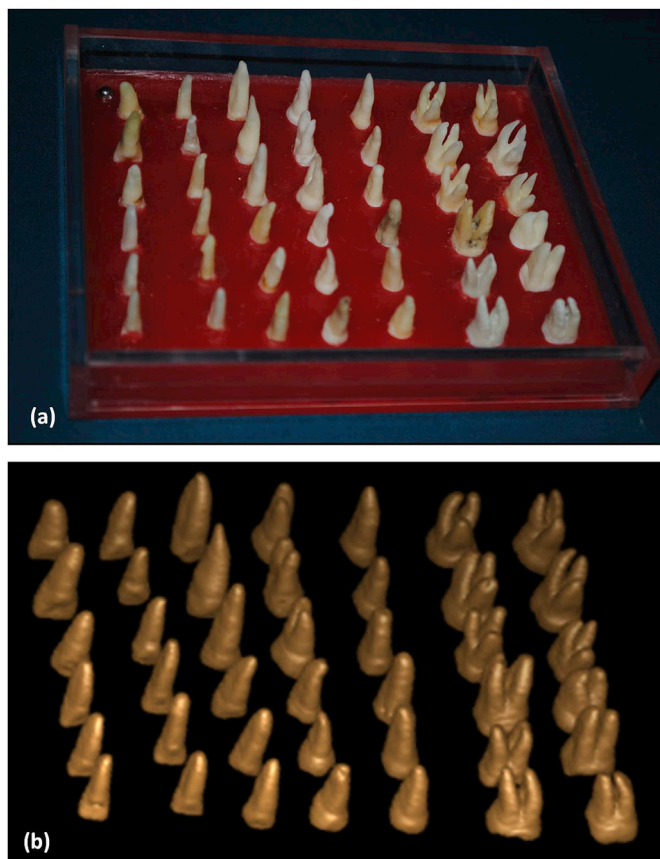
(a): Sample of extracted teeth mounted on a customized acrylic jig with wax filler for easy placement of the teeth. (b): CBCT-acquired 3D image on the same sample of teeth.
